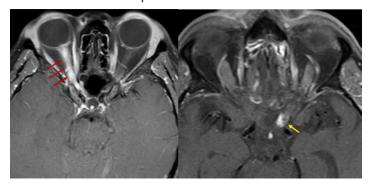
On the left is a T1 post-gadolinium MRI axial image demonstrating avid, homogeneous enhancement of the entire left optic nerve in a patient with MOGAD. On the right is a post-gadolinium MRI axial image of a patient with radiation of optic neuropathy exhibiting focal enhancement (arrow) at the junction of the left optic nerve and chiasm, 18 months following high dose radiation to the parasellar region.
